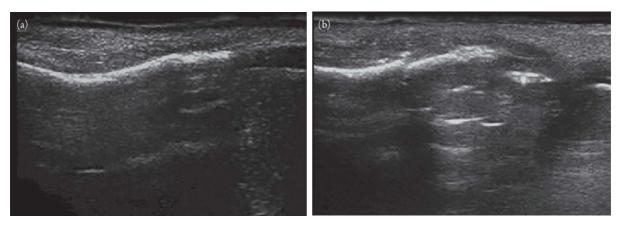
(a) Ultrasound image of normal nasal bone. Note the hyperechoic bony structure that is intact. Adapted from Figure 3 of Caglar B, Serin S, Akay S, et al. The accuracy of bedside USG in the diagnosis of nasal fractures. *Am J Emerg Med.* 2017;35(11):1653–1656. doi:10.1016/j.ajem.2017.05.015. (b) Ultrasound image of nasal bone fracture. Note the hyperechoic bony structure with cortical disruption and mild superficial edema. Adapted from Figure 4 of Caglar B, Serin S, Akay S, et al. The accuracy of bedside USG in the diagnosis of nasal fractures. *Am J Emerg Med.* 2017;35(11):1653–1656. doi:10.1016/j.ajem.2017.05.015.
